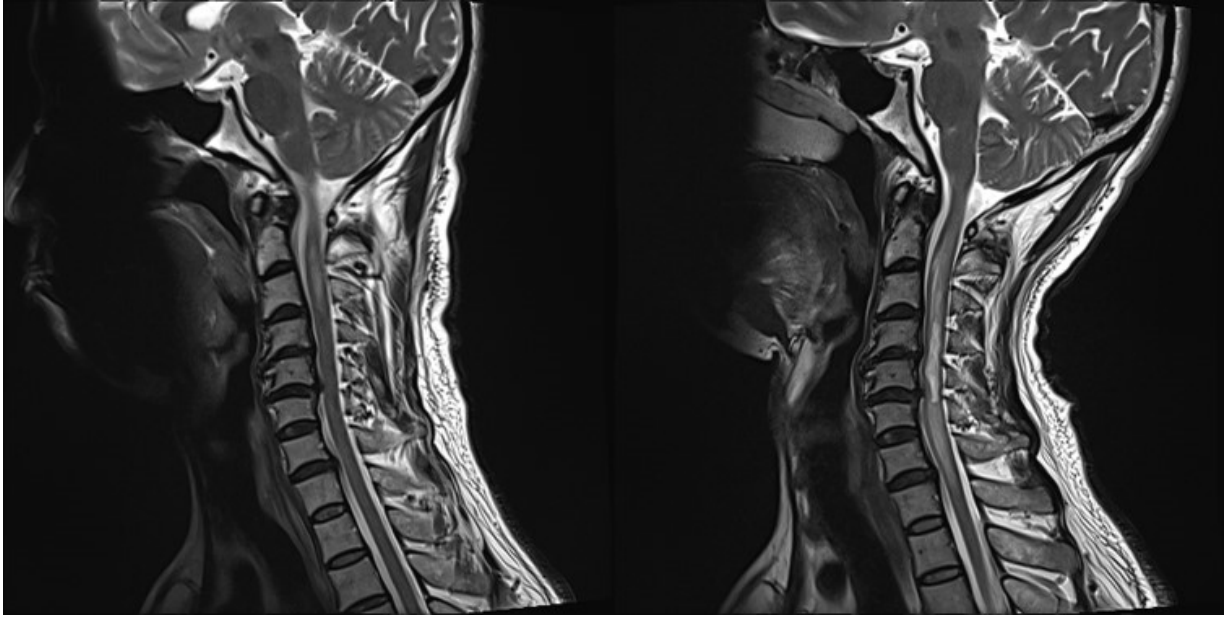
Initial and follow up cervical spine magnetic resonance imaging (MRI) in sagittal plane
